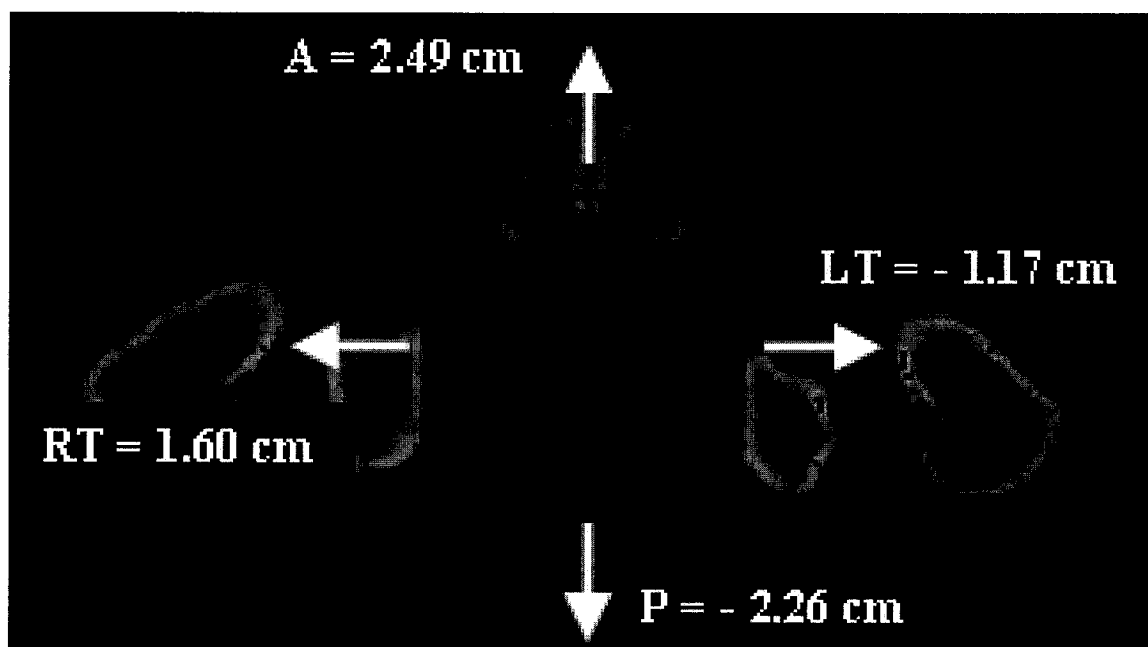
Maximum prostate PTV shifts on an axial CT-slice through patient 11. Shown are the PTV at the isocenter (heavy line) and shifted (lighter lines).
